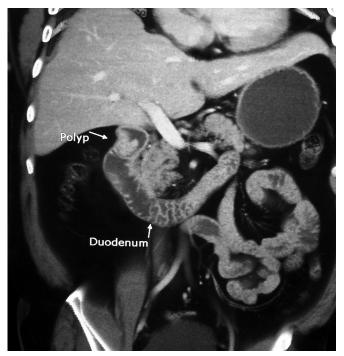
CT scan of the lesion.
